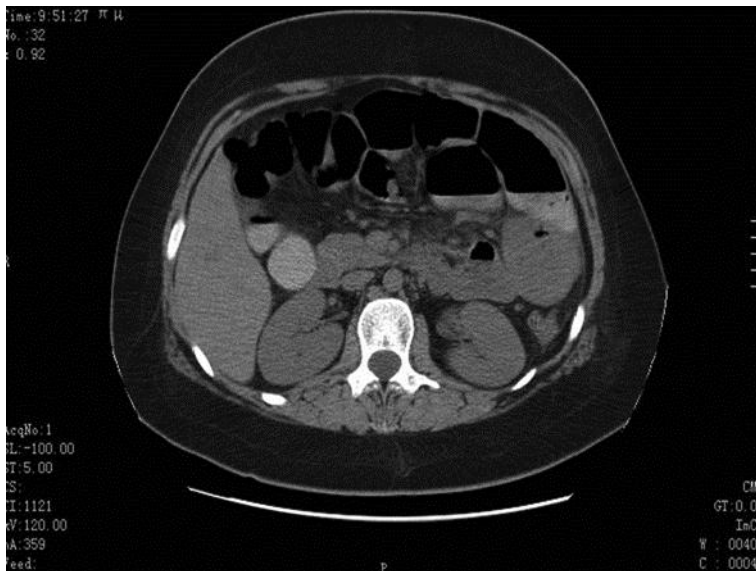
CT imaging of the abdomen, revealing evident distension of the bowel loops, with no sign of mechanical obstruction.
